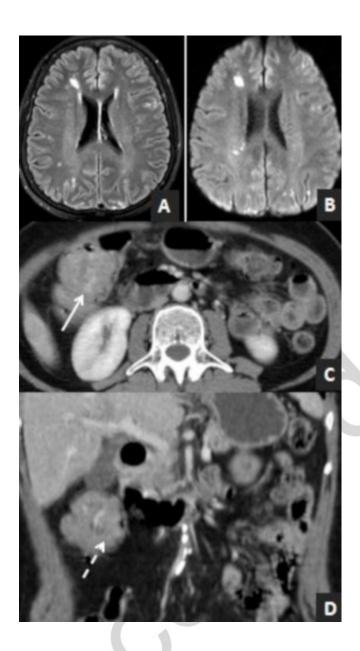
Brain magnetic resonance imaging (MRI) showed multiple hyperintense foci in subcortical and cortical regions involving three different vascular territories in the FLAIR sequence (Figure 1 A), associated with restricted diffusion (Figure 1 B) inferring cytotoxic edema and indicating that they were all recent ischemic lesions, raising the hypothesis of TS. Abdominal Computed Tomography (Figure 1 C, D) showed thickening of the ascending colon compatible with an expansive tumor.
